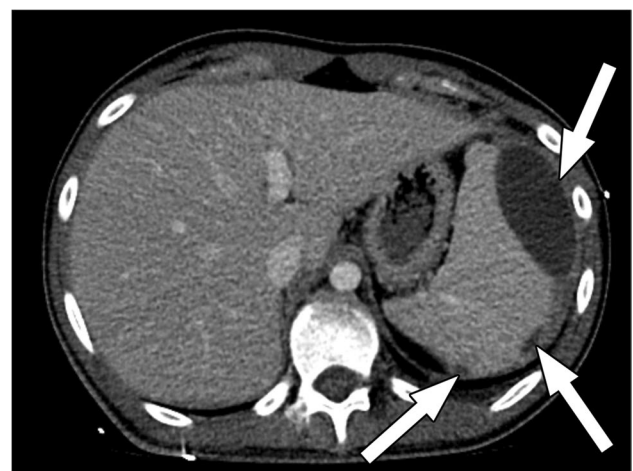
17-year-old boy with disseminated histoplasmosis and splenic involvement. Axial abdominal CT image with IV contrast material shows multiple infectious subcapsular splenic fluid collections (arrows)
